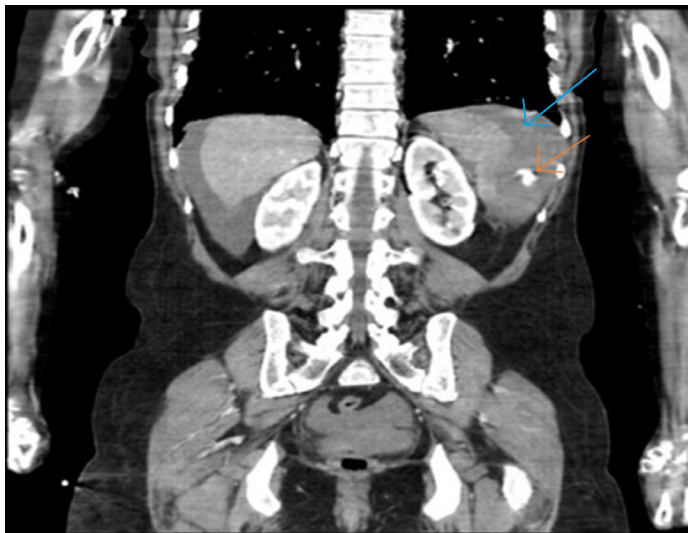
Coronal CT section. Blue Arrow: Active splenic hemorrhage, Orange Arrow: Splenic laceration
